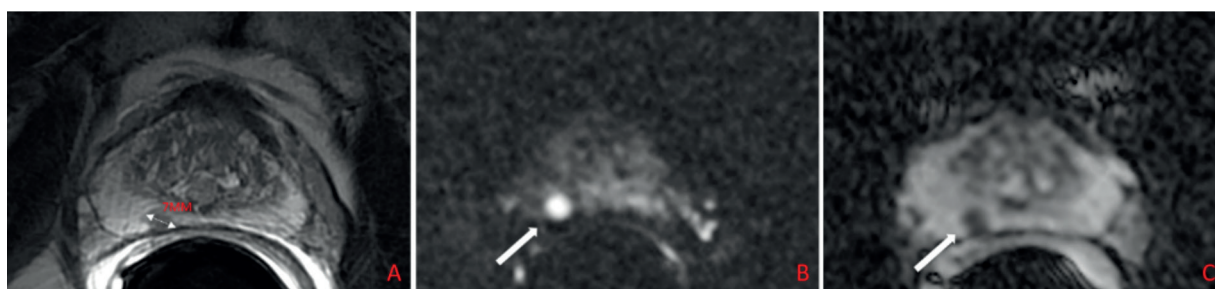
A 7 mm rounded lesion (arrow) in dorsally peripheral zone of the mid-portion of the prostate on the right (A). This lesion was assigned to PI-RADS category 4, based on a 7 mm lesion (<1.5 cm), markedly hyperintense on DWI (B) (b3000 s/mm²) and hypointense on ADC (C) (score 4 - dominant sequence), correlated to moderately hypointense on T2WI (A).
